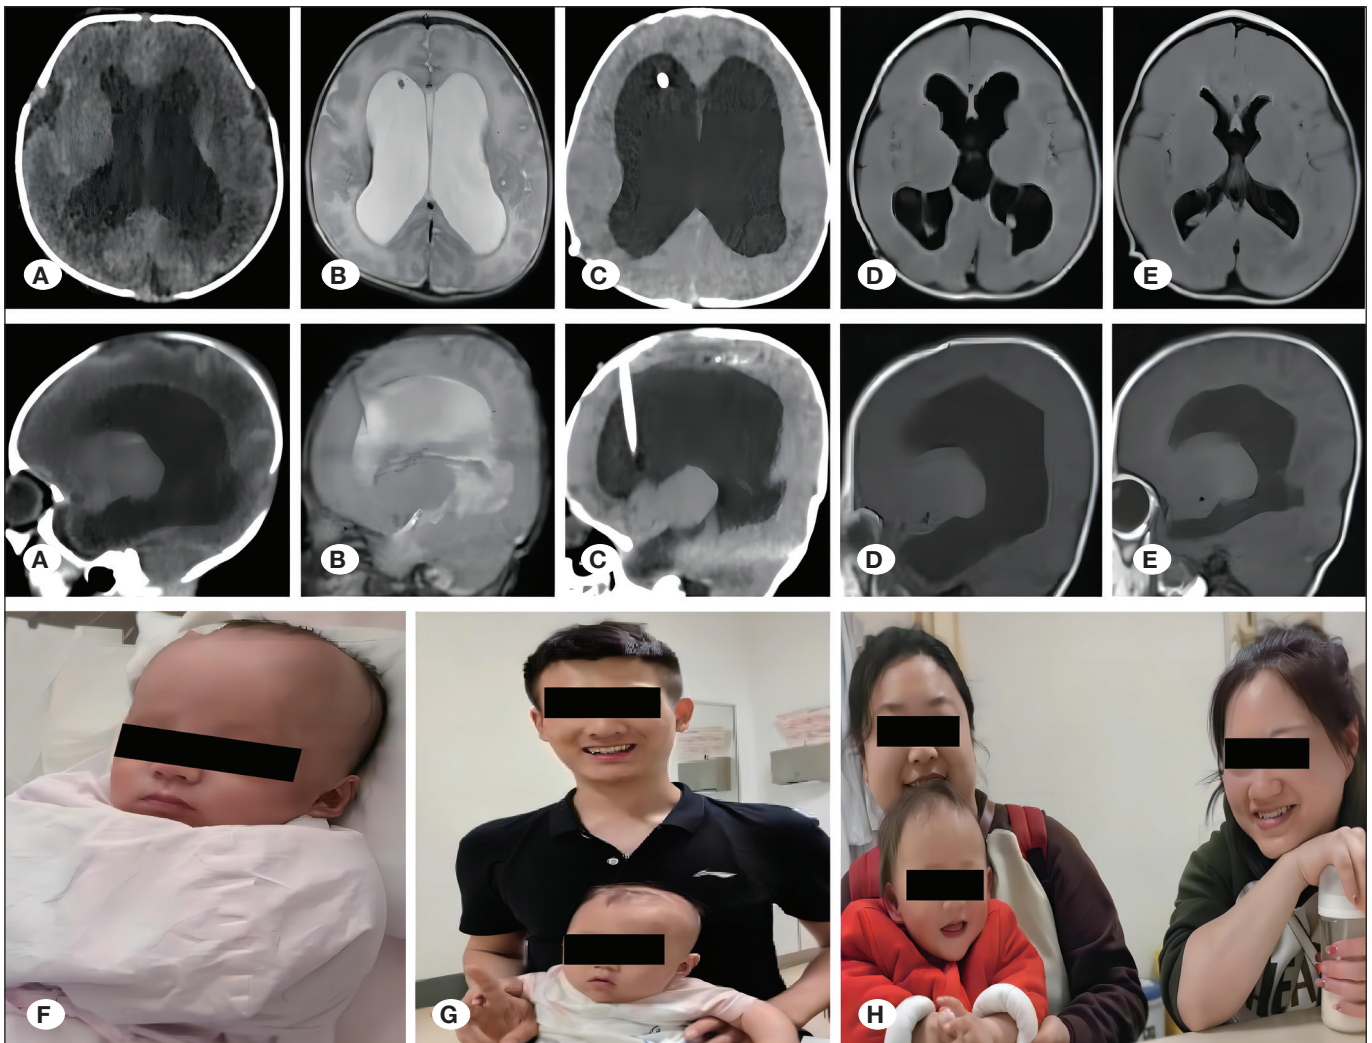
Radiographic and superficial presentation of typical cases at different time points during the perioperative process. A&F: Two sections of the patient before operation I showing the enlargement of ventricle expanded head circumference performance. B) Two section of patient after ommaya revisor implantation. C) Two section of patient after Ventriculoperitoneal shunt (VPS). D&G) 4 months after VPS indicating the normal ventricles and the performance of the child's reduced head circumference. Information of patient were erased to avoid leaking information. Patient information was erased to avoid leaking information. E&H) 1 year after VPS indicating the normal ventricles and the satisfaction of parents. Patient information was erased to avoid leaking information.
